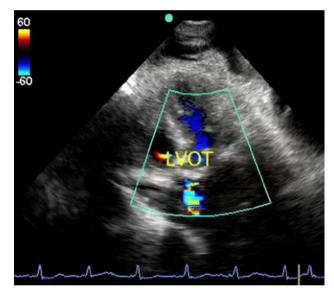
Critical aortic stenosis color Doppler apical 5-chamber view
